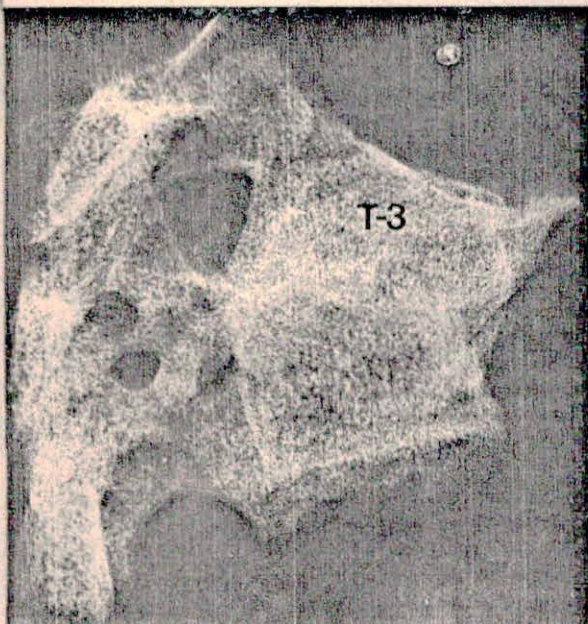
Case 3. Lateral roentgenogram of T-3, T-4, and T-5.
